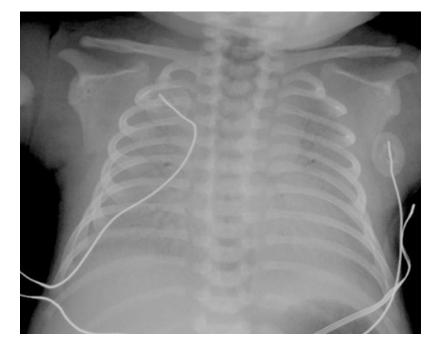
RDS. Frontal chest radiograph shows complete opacification of lungs with indistinctness of the cardiomediastinal silhouette secondary to atelectasis
